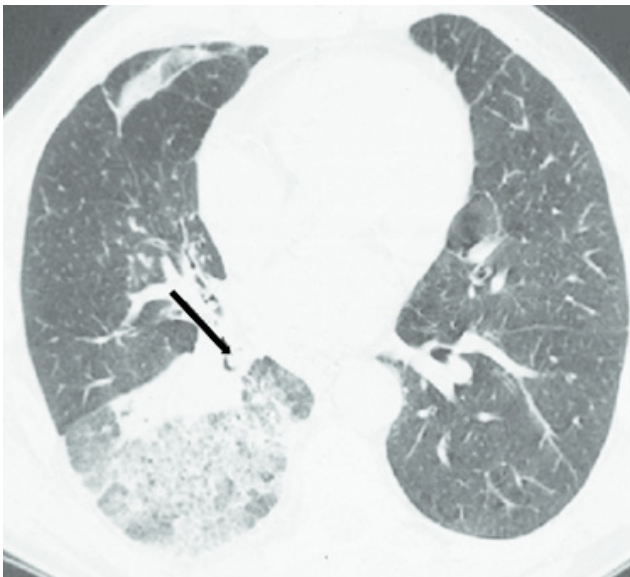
Endobronchial mass in chest CT scan.
